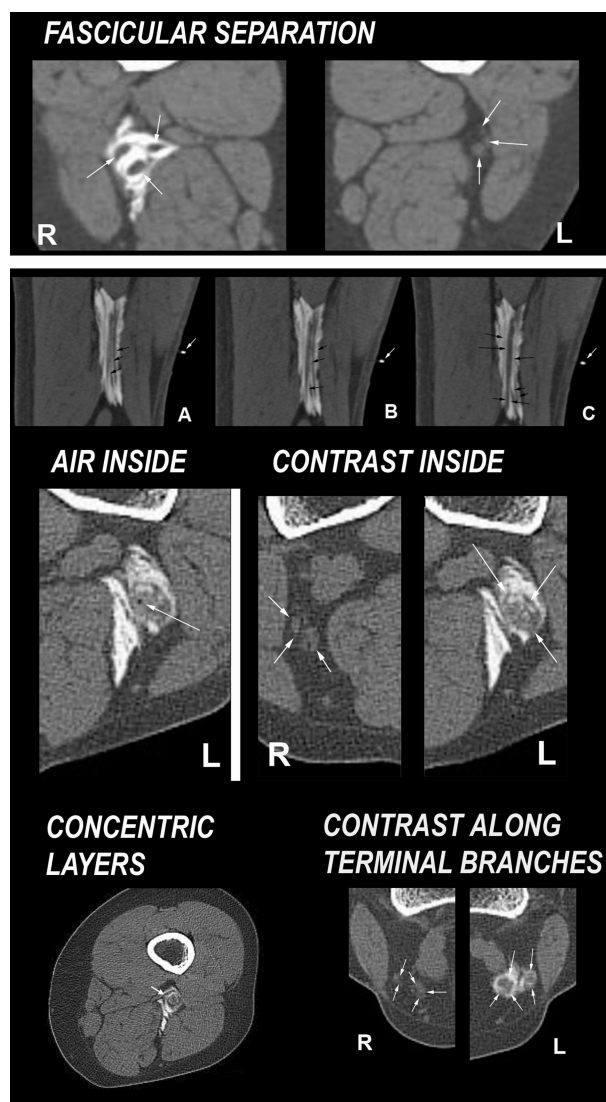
Computed tomography (CT) scan signs used to define intraneural injection criteria. CT images of the sciatic popliteal nerve after the injection demonstrates fascicular separation at the injection level, the presence of air or contrast inside the nerve, concentric layers of contrast around the nerve, and contrast following both bifurcations distally to the injection level.
